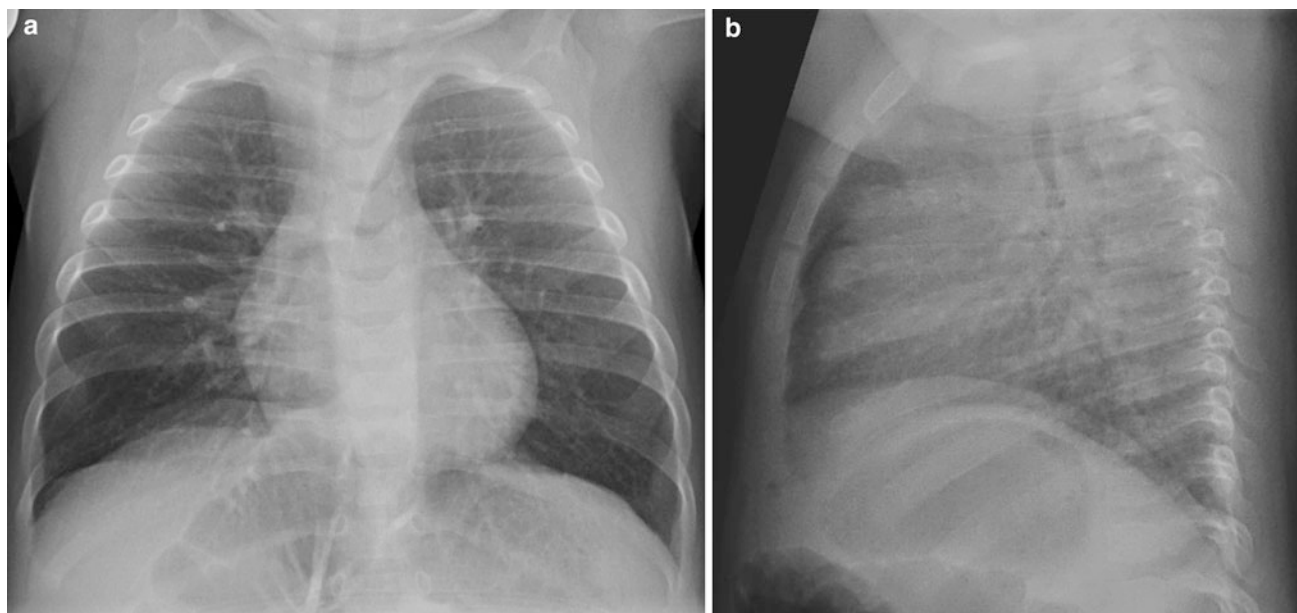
Frontal (a) and lateral (b) chest radiographs of the same child obtained within minutes. The frontal view shows flattened hemidiaphragms but in the lateral view the diaphragms are in normal high position, which rules out air trapping
